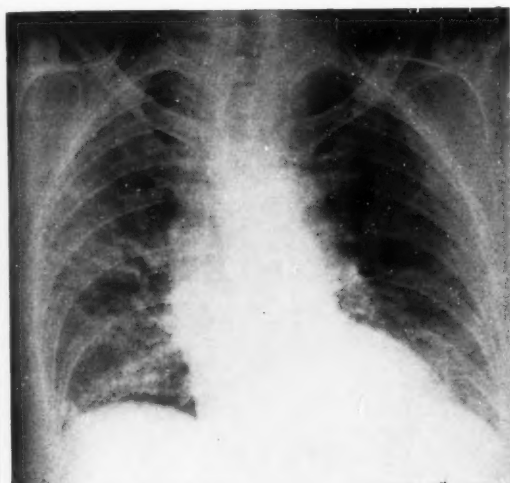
(a) — Marked Reaction — Mrs. L. M., 67 yrs; quadrat radiation to right chest to a dose of 6000 r in 78 days. Chest X-ray made at the time when treatment was terminated because of the development of severe clinical signs and symptoms of radiation pneumonitis. Note extensive infiltration with some loss of volume, but little tendency to consolidation.
